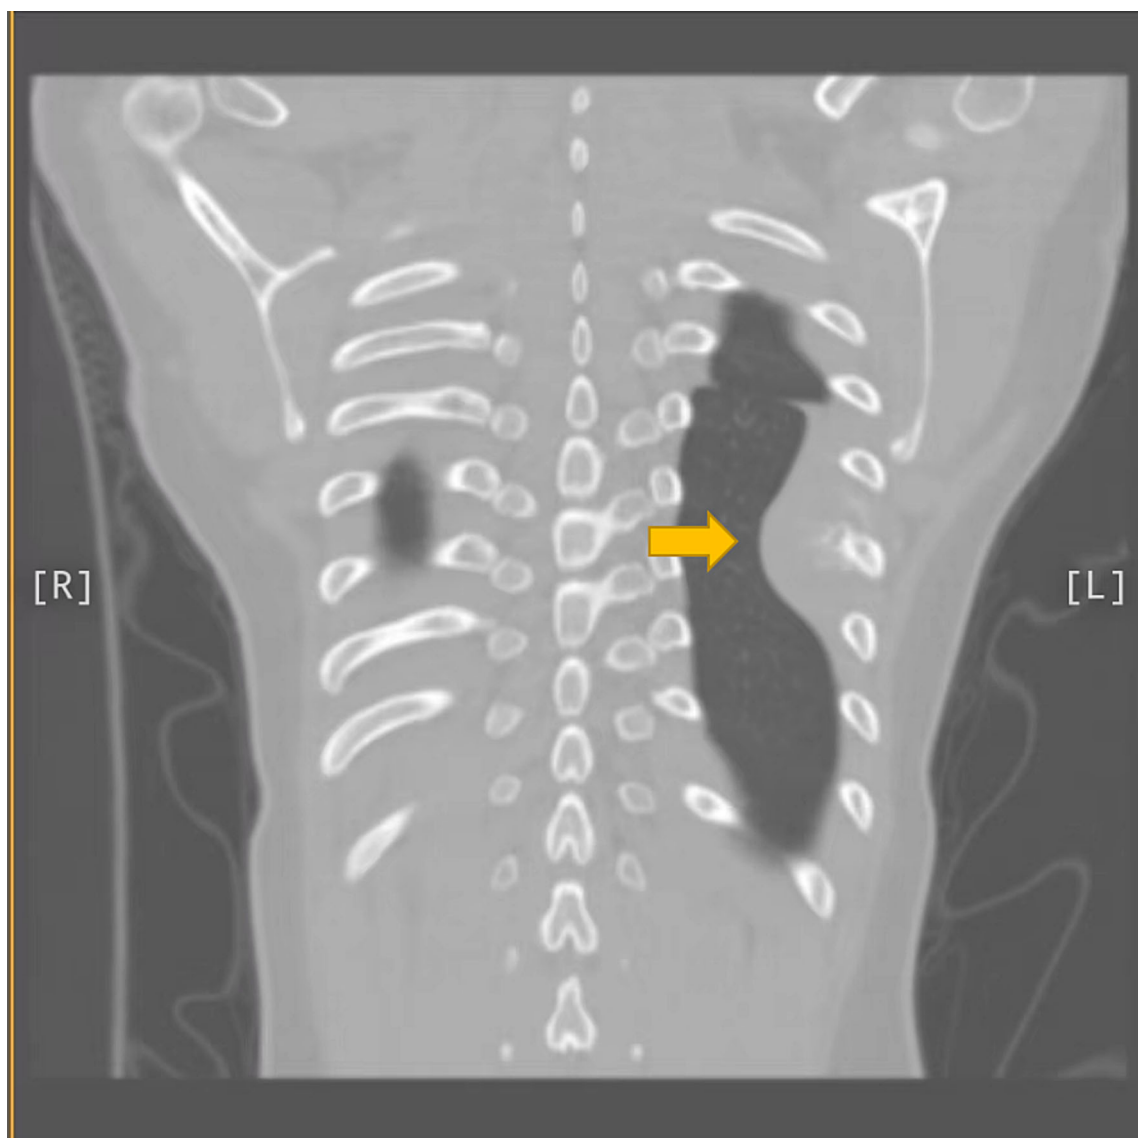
Preoperative coronal CT of patient. Notice a semicircle mass (pointed by yellow arrow) on left hemithorax and destruction of the seventh ribs.
